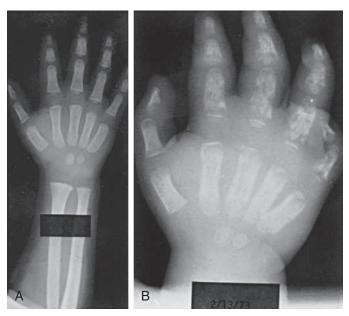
Radiographs of an infant with sickle cell anemia and acute dactylitis. A, The bones appear normal at the onset of the episode. B, Destructive changes and periosteal reaction are evident 2 weeks later.
